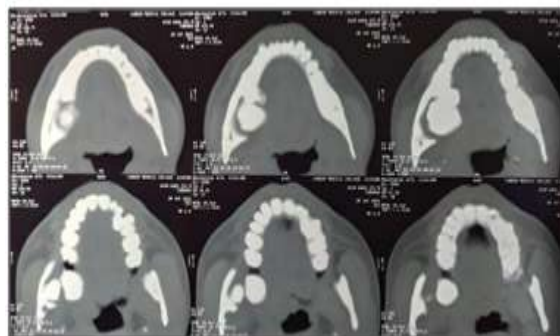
Axial view of Computed tomography showing lingual cortex perforation.
